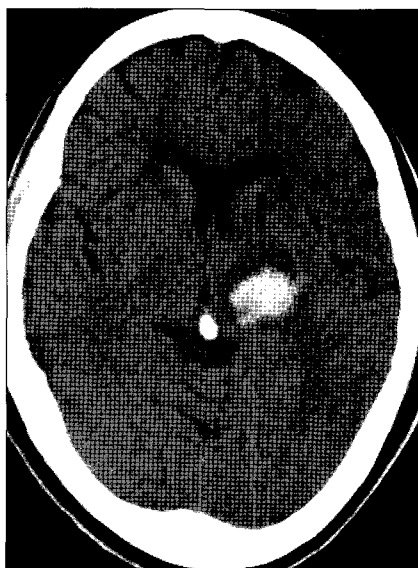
Initial brain computed tomography revealing an intracerebral hemorrhage in the left thalamus.
